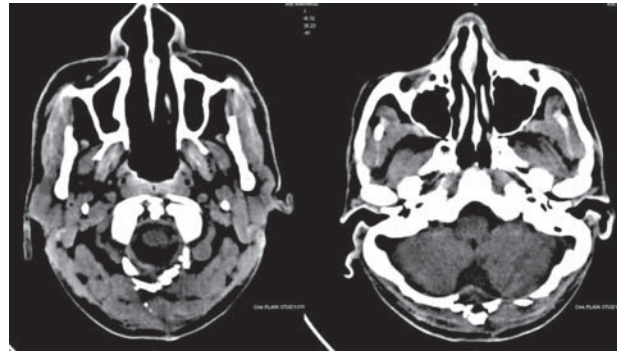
Post-operative CT scan showing complete evacuation of hematoma.
